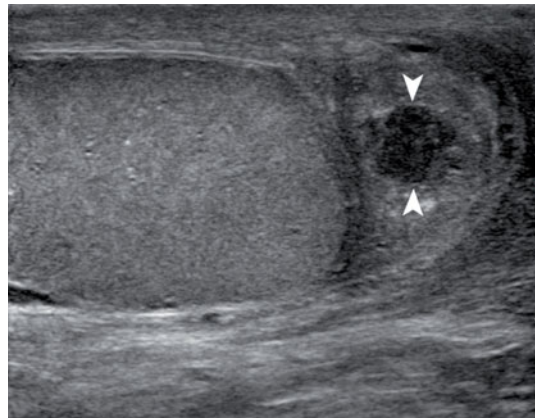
Epididymal abscess. A liquid area is visible in the tail of epididymis (*arrowheads*) which shows no vascular supply on color Doppler
